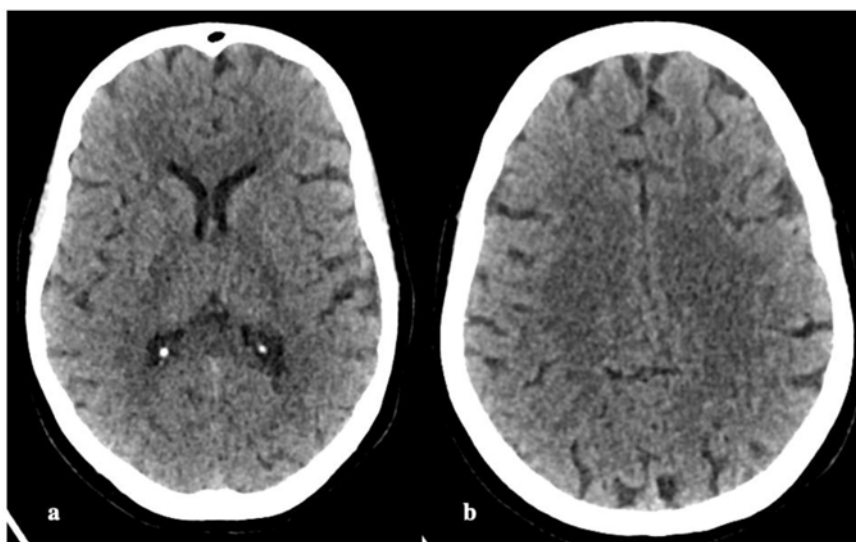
Non-contrast computed tomography of the head at the level of the basal ganglia (a) and centrum semiovale (b) does not show any obvious abnormalities.
